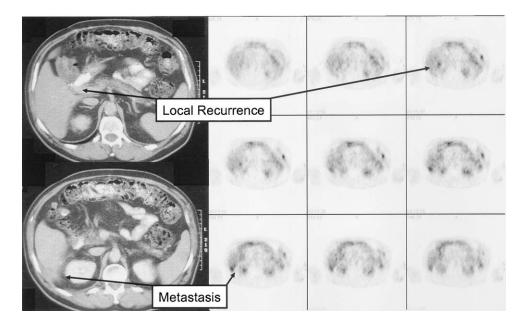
Example of FDG-PET imaging in a patient undergoing surveillance after resection of cholangiocarcinoma. The PET images demonstrate two focal areas of FDG uptake corresponding to a local hilar recurrence and a hepatic metastasis retrospectively seen on CT.
